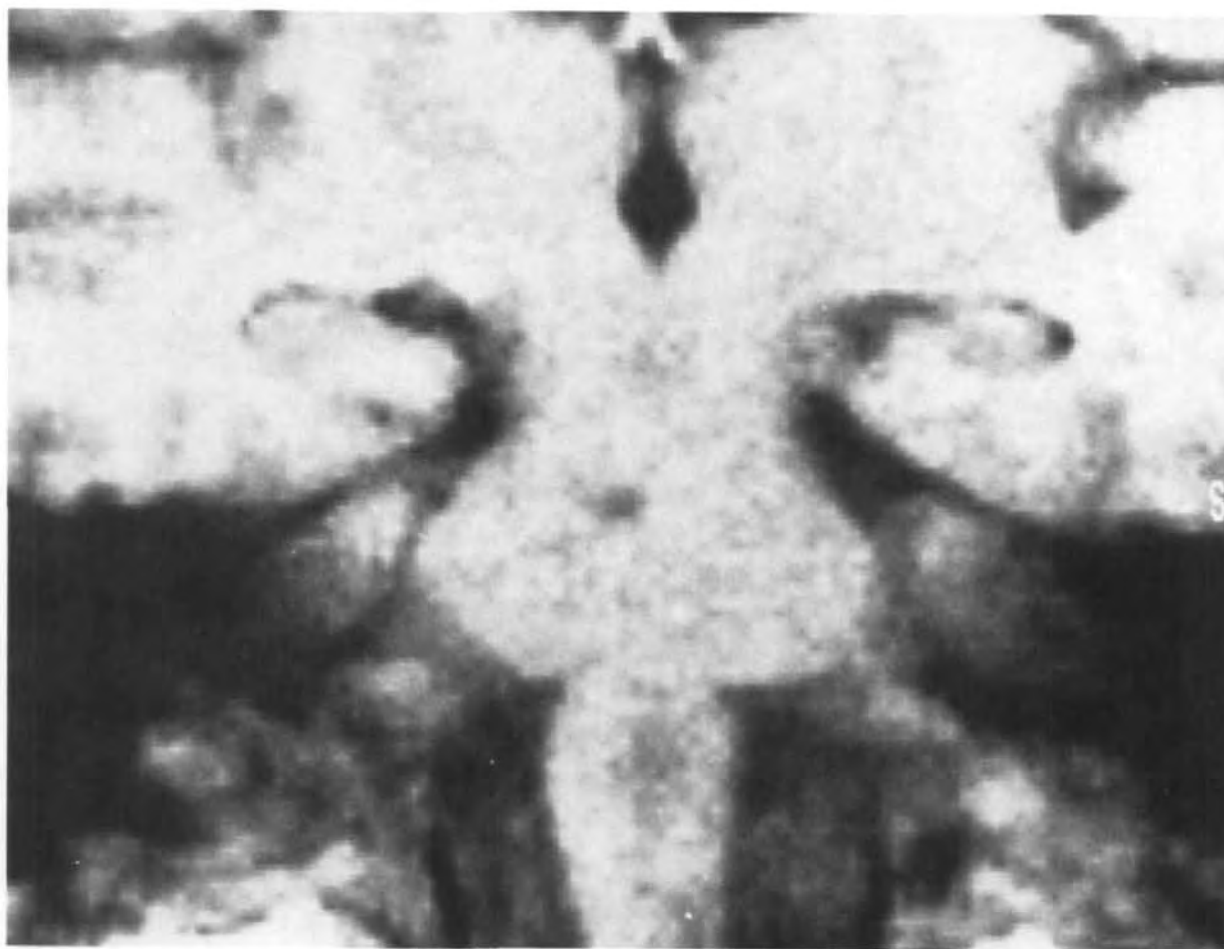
Frontal T1-weighted magnetic resonance image showing hypointense signal in right paramedian area at junction of upper one third and lower two thirds of pons in 53-year-old hypertensive man with pure sensory stroke.*
